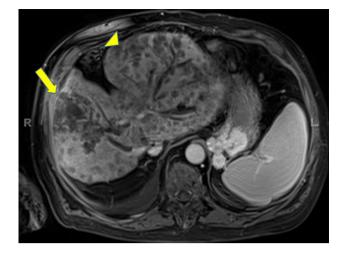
T1-weighted MRI of abdomen during portal venous phase demonstrating increase in size of the index lesion in segment V/VI to 9.4×8.0 cm (*arrow*), as well as innumerable new nodules throughout both lobes of the liver (*arrow head*)
